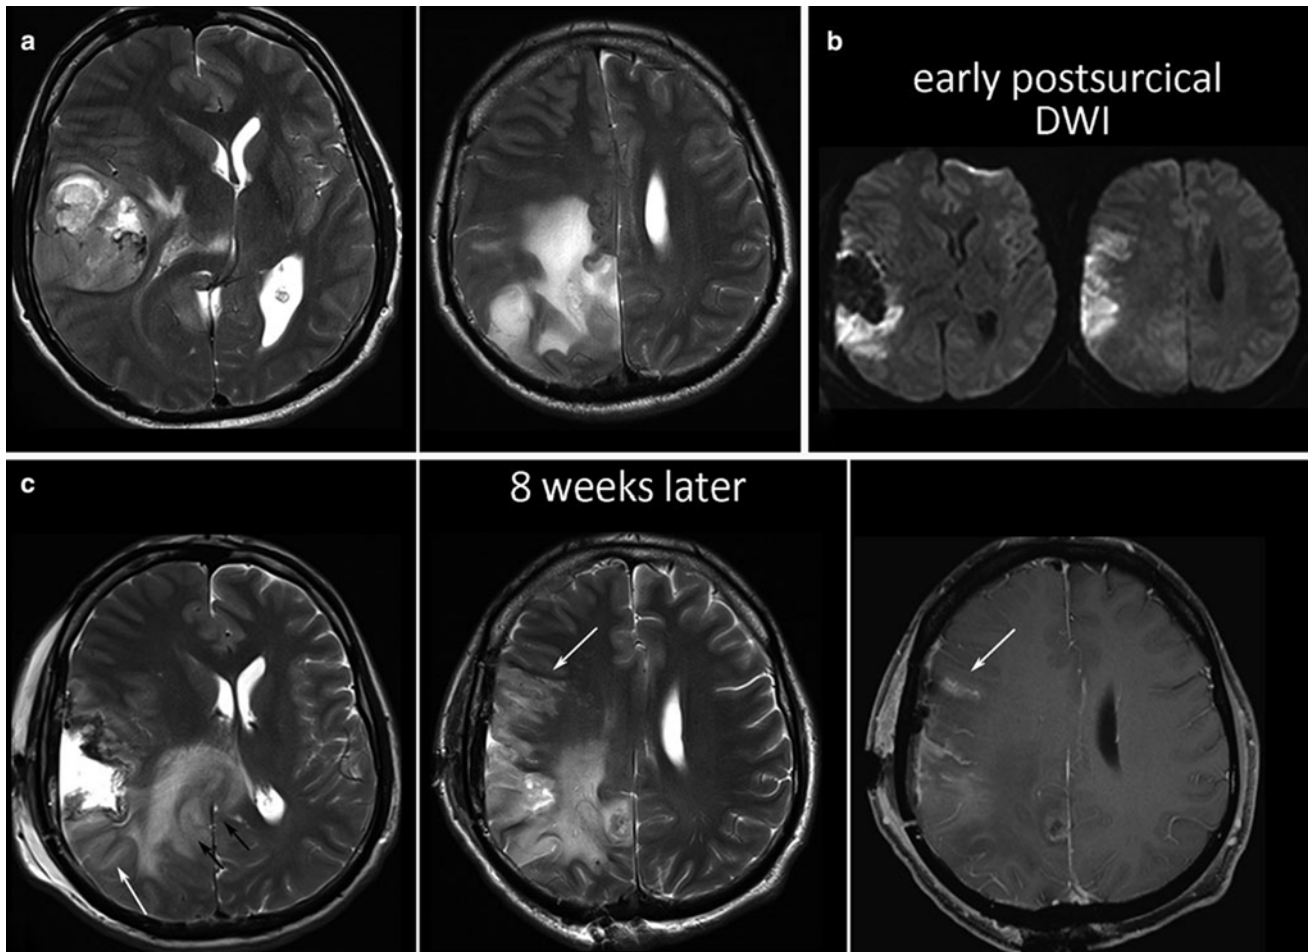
Presurgical scan of a huge GBM before resection of the lateral and parietal tumor parts (a), postsurgical DWI (b), and the MRI control 2 months thereafter (c). There is a clear tumor progression thickening
